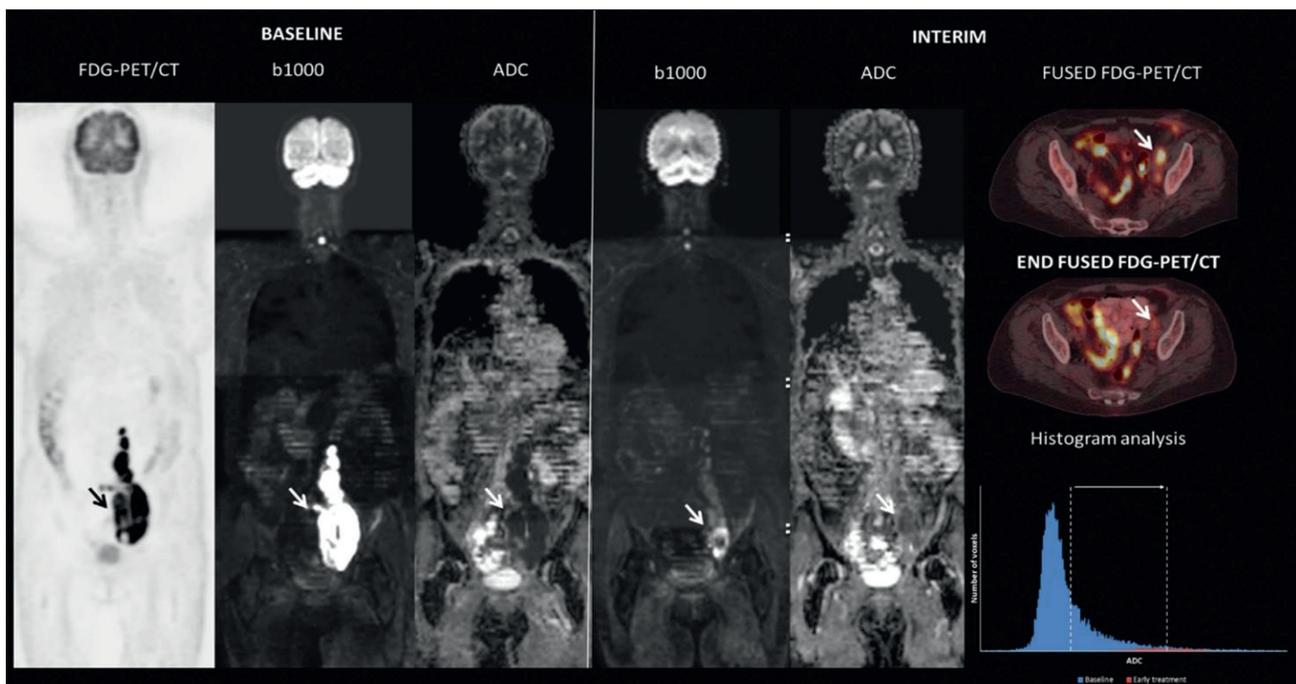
Example of a patient with diffuse large B-cell lymphoma (DLBCL) showing a large retroperitoneal-iliac mass, which demonstrated good treatment response. At baseline, the mass shows high FDG-uptake, high b1000 signal intensity and inversely low ADC value on the calculated ADC-map. After three weeks of therapy (one cycle of R-CHOP), b1000 SI of the mass has clearly decreased (and increased on the ADC-map), with the associated ADC histogram showing a significant ADCmean increase of the lesion, rendering this a responding patient. In contrast, the lesion demonstrated persistent FDG-uptake on both interim (after three cycles) and end-of-treatment FDG-PET/CT, and was consequently categorised as non-responder. No further therapy was initiated owing to reassuring clinical findings and blood results, and the patient has remained in complete remission till the end of follow-up (48 months).
